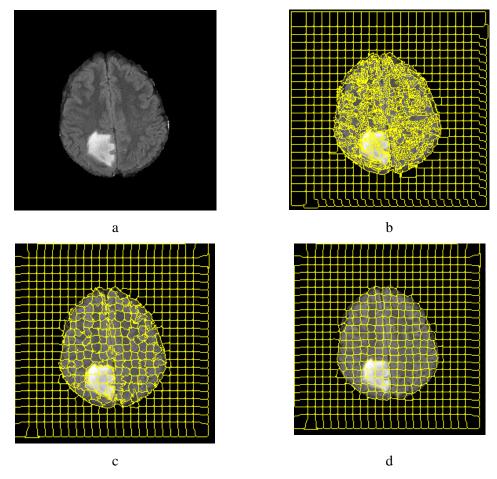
Superpixel segmentation for one slice of the MRI image different compactness factors: a) original MRI FLAIR image with a Grade II tumour, b) superpixel segmentation with m=0 and S=10, c) superpixel segmentation with m=0.2 and S=10, d) superpixel segmentation with m=0.5 and S=10.
